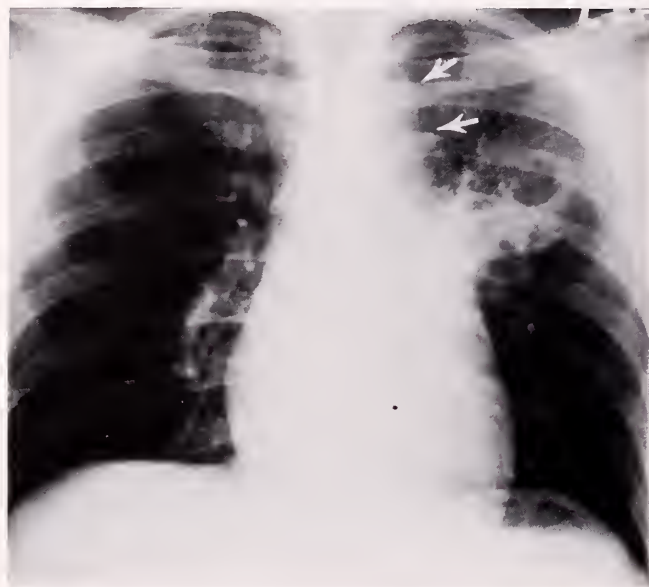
Primary tuberculosis in a 26-year-old black male. Posteroanterior (A) and lateral (B) radiographs demonstrate a cavitary infiltrate in the anterior segment of the left upper lobe. There is also paraaortic lymphadenopathy (arrows).
